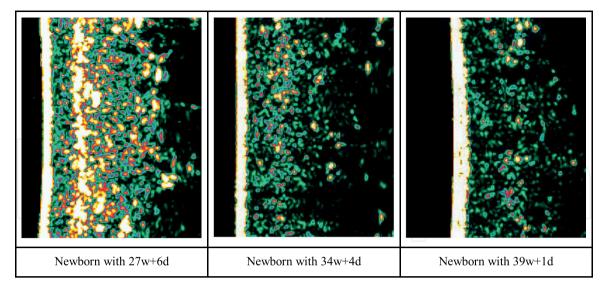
High-frequency ultrasonography image of the skin over the forearm. Note: Epidermis corresponds to the white layer at the left side, resolution: $356- \times 276$ -pixel. Source: The authors.
